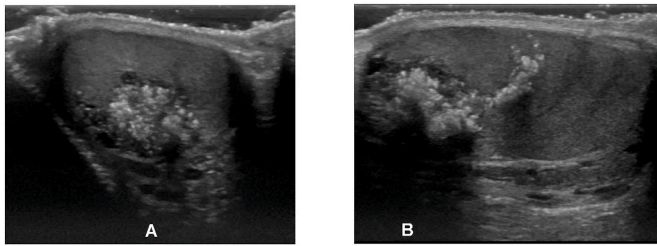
Ultrasonography of the right testicle with intratesticular mass, (A) superior to inferior, (B) lateral to medial views.
